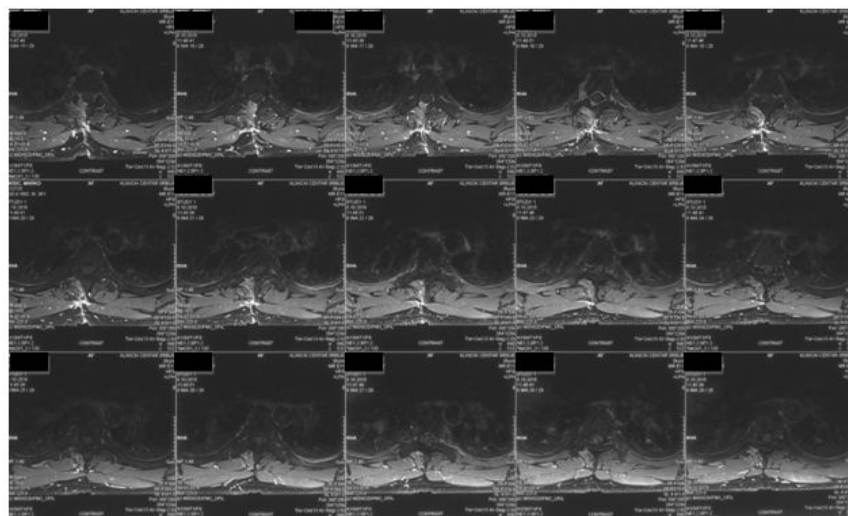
(postoperative MRI axial T1 with contrast)
